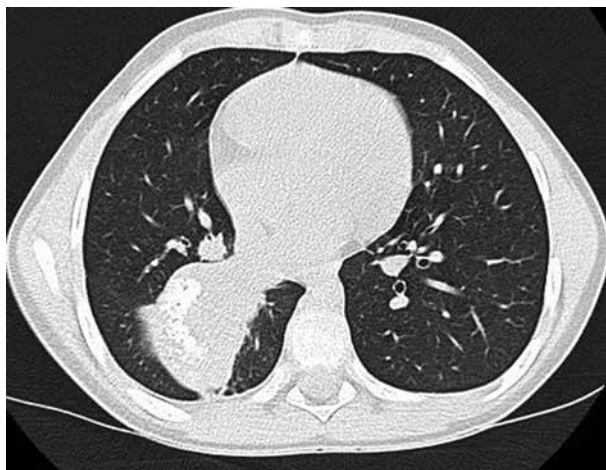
Computed tomography of the inflammatory myofibroblastic tumor of the lung. CT image shows presence of a nodule-like lesion with calcifications in the right lower lobe
